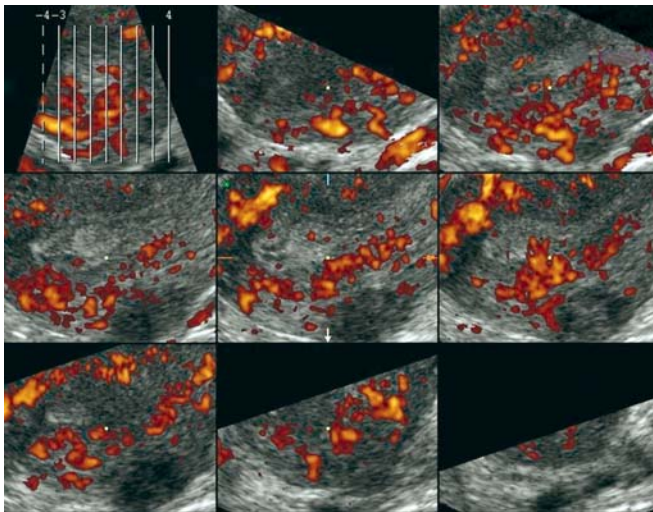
Grey scale and power Doppler 3D acquisitions may be displayed in a tomographic sectional format akin to CT and MR. This format permits excellent localization and identification of pathological lesions and vascular signals
